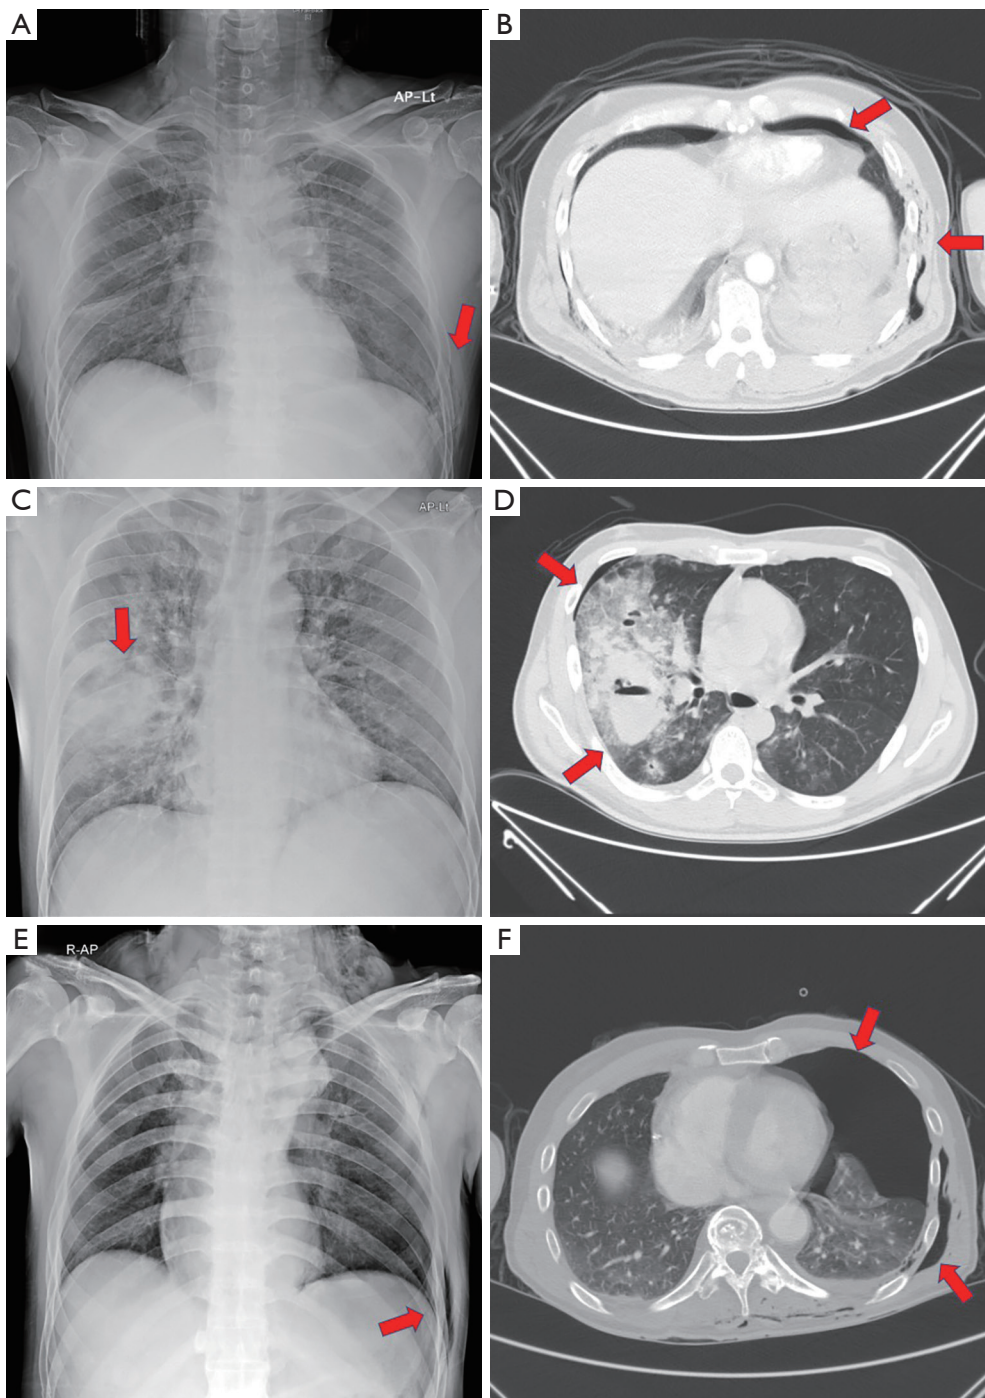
Various supine chest radiography and chest computed tomography findings of occult pneumothorax in Blunt chest trauma. (A,C,E) Arrows show the subcutaneous emphysema, rib fracture and lung contusion in supine chest radiography. (B,D,F) Arrows show the subcutaneous emphysema, rib fracture, lung contusion and traumatic pneumothorax in same patient. AP, anterior-posterior; Lt, left; R, right.
